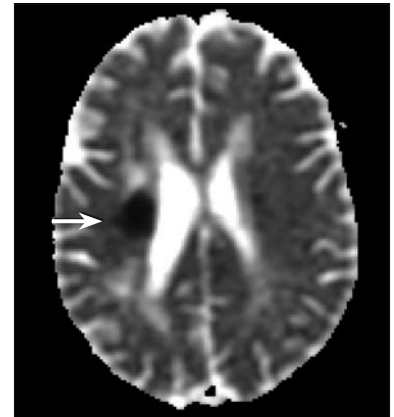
Axial apparent diffusion coefficient MR image shows right periventricular white matter hypointensity (arrow), which confirms that the diffusion-weighted hyperintensity is restricted diffusion and not T2 hyperintensity “shine through.”
